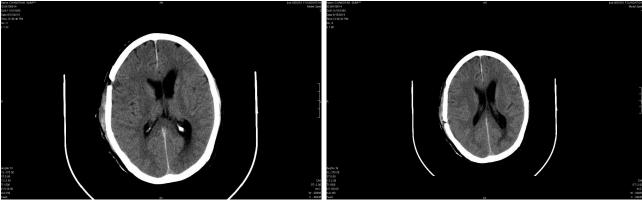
Post Operative CT Brain showing the hematoma was removed
